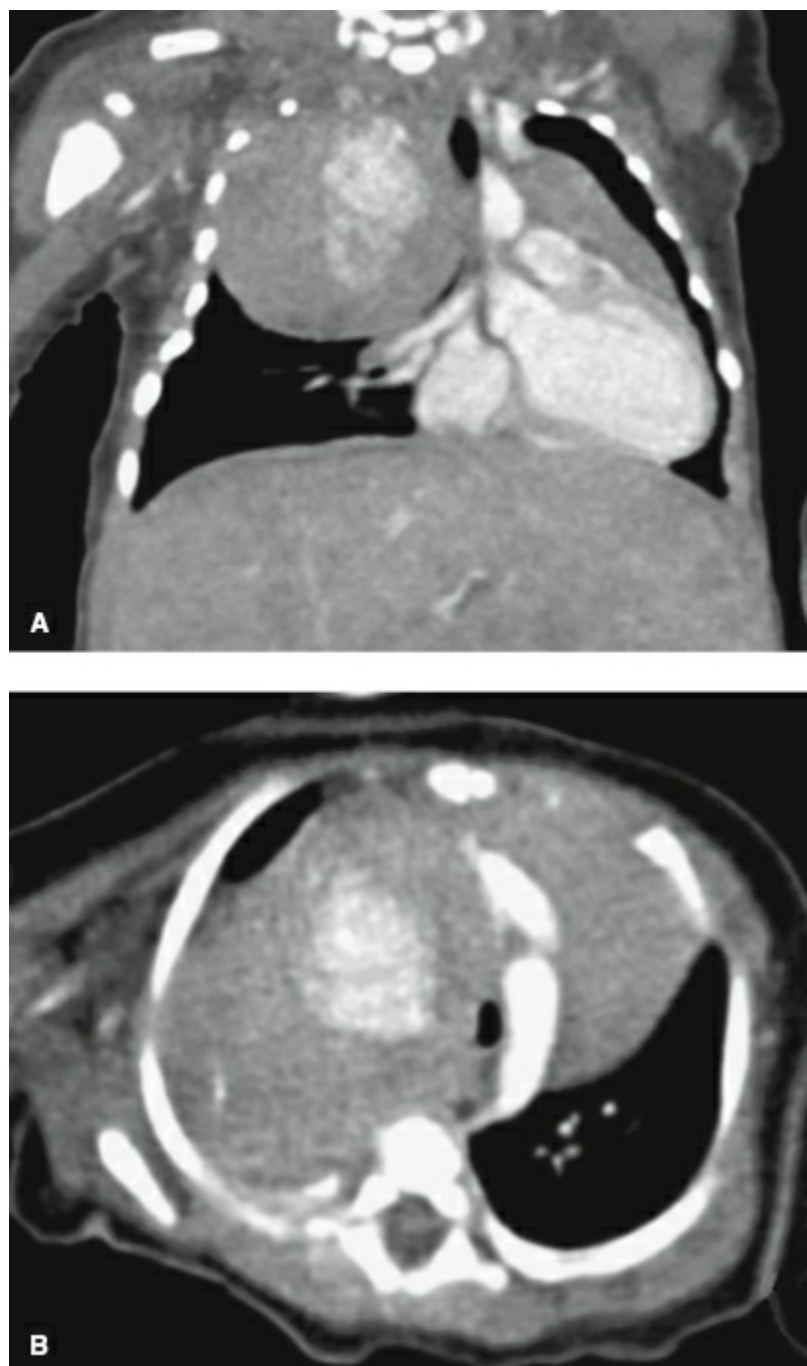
A: Large neural tumor in coronal view CT scan with calcifications (neuroblastoma). B: Same mass on transverse view.
